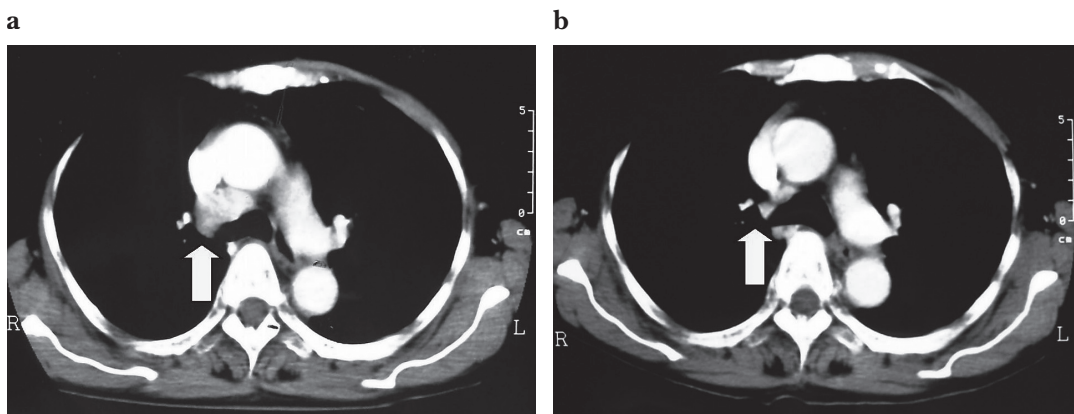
a: Chest CT scan shows mediastinal lymphadenopathy.
